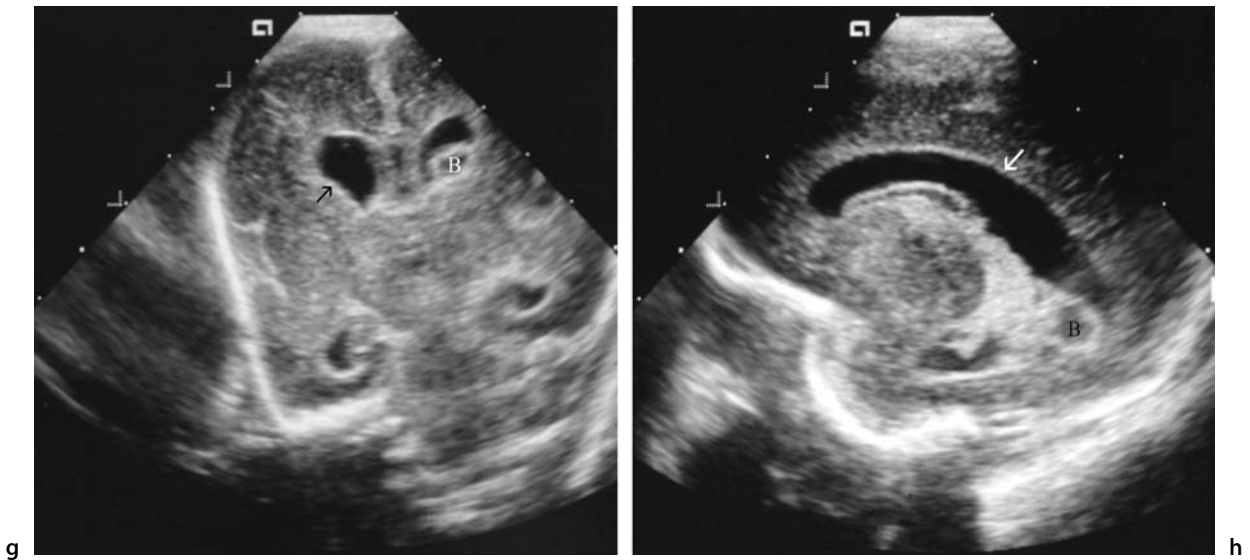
Ultrasonography of the neonatal brain
